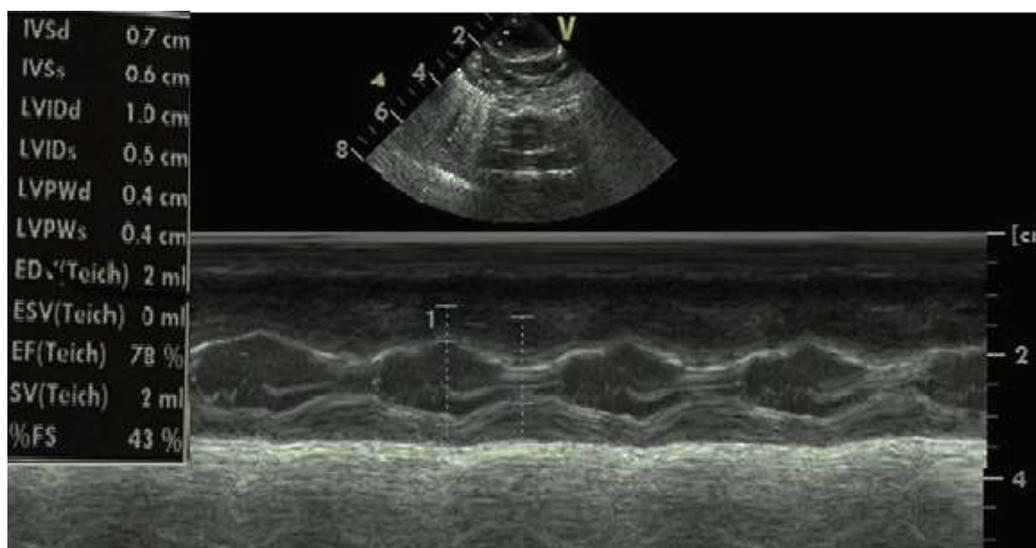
Echocardiography showing interventricular septum thickening (IVSd Z 0.7 cm)
